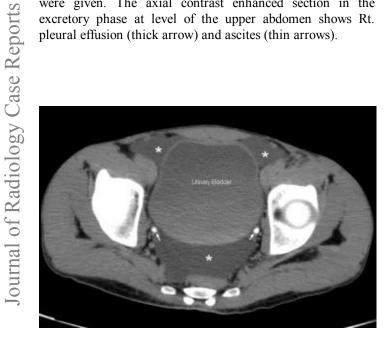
Abdomen CT scan of a 22 male patient with renal lymphangiectasia. The examination was done by Brilliance 64 Philips machine; kV 120.0, mAs 246 and 3 mm slice thickness. Oral contrast and 70 ml IV contrast (Ultravist) were given. The axial contrast enhanced section in the excretory phase at level of the pelvis shows ascites (asterisks). Ureters are filled with contrast (arrows).
